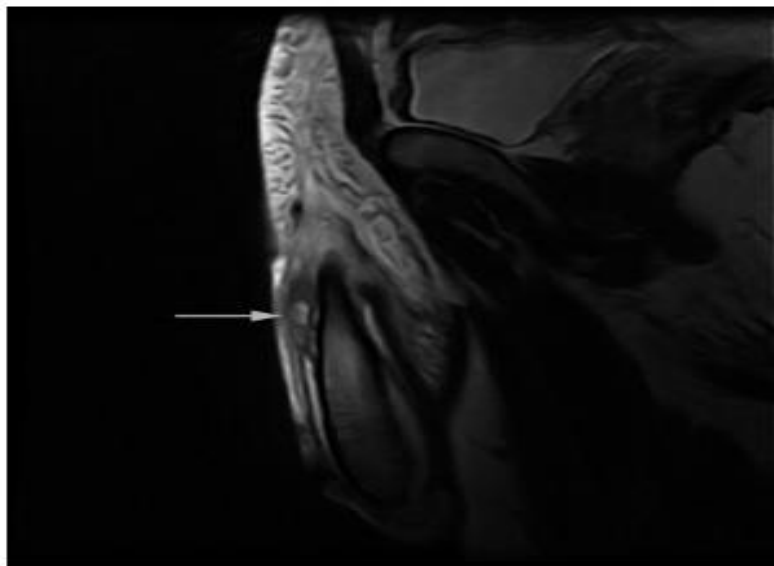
Reformatted sagittal oblique T2-weighted MRI of penis showing left corpus cavernosum with intact tunica albuginea. There is a small subcutaneous hematoma of mixed hypo- and hyperintense signal intensity anterior to the corpus cavernosum (arrow).
